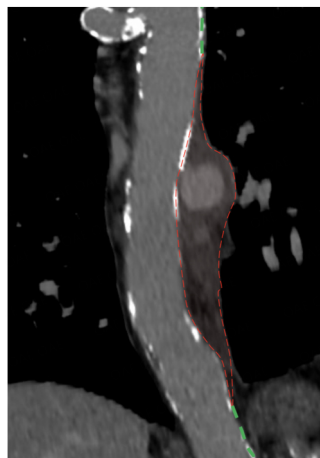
CTA with multiplanar reconstruction of a penetrating aortic ulcer (zone 5) with associated intramural hematoma. Dashed red line highlights its proximal and distal extension; recommended landing zone should be at the level of the green dashed line.
